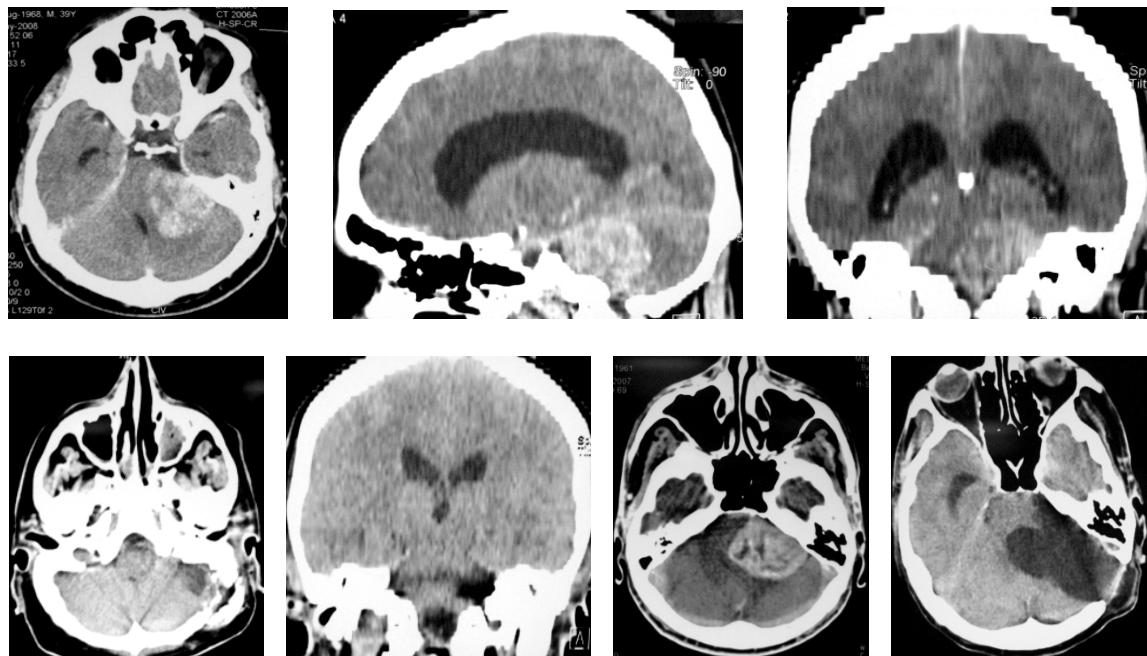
Preoperative cerebral CT showing giant VS (51 mm) with obstructive hydrocephalus (A-C); postoperative cerebral CT after 1 year follow-up showing complete resection (D, E); another case with giant VS (57 mm) showing pre and postoperative CT
